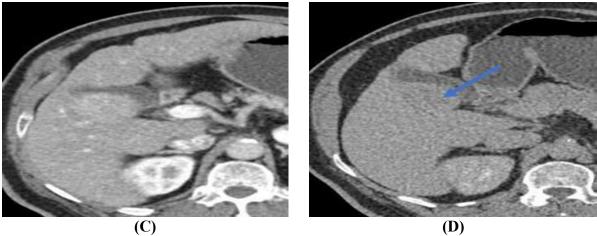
(A) Axial CT images prior to contrast administration, (B) after contrast administration at arterial phase, (C) Porto Venous phase and (D) delayed phase reveal hepatic cirrhosis, focal lesion in the Rt lobe at segment V measure 45 mm show enhancement at arterial phase (detected by the red arrow) with enhancing capsule and wash out at delayed phase (blue arrow)
